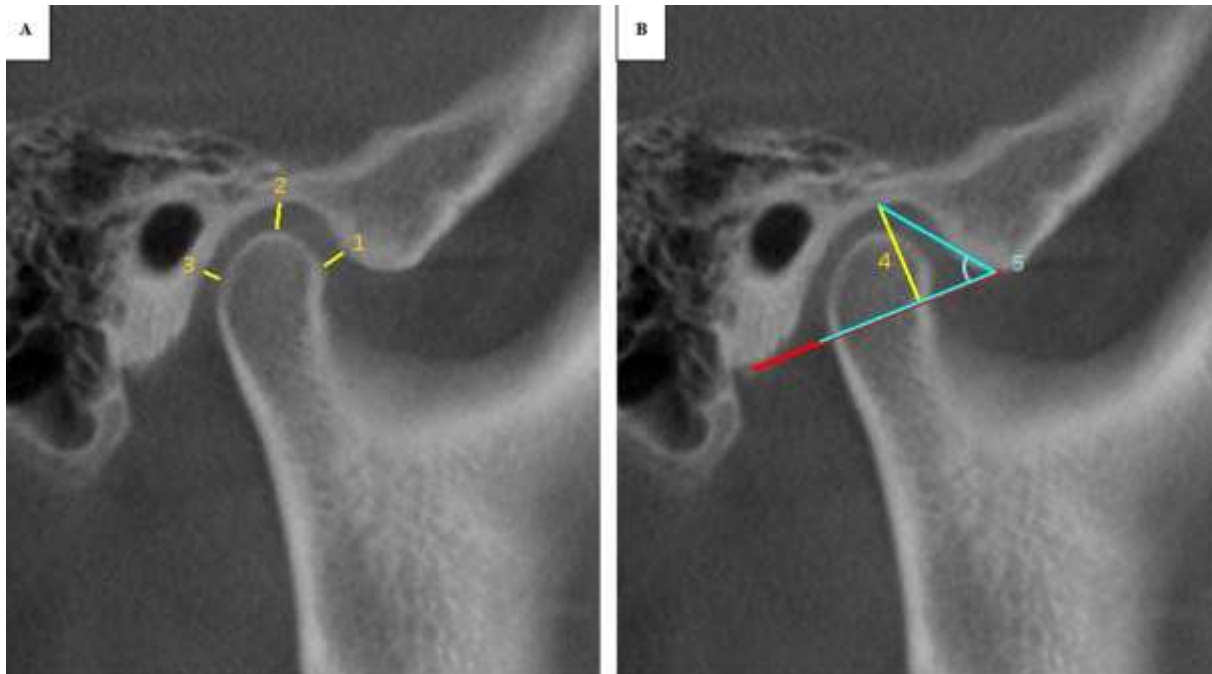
Sagittal measurements. (A) 1, Anterior joint space; 2, superior joint space; 3, posterior joint space measured by i-CATvision CBCT software; (B) 4, depth of the mandibular fossa; 5, angulation of the posterior wall of articular tubercle measured by ImageJ software
